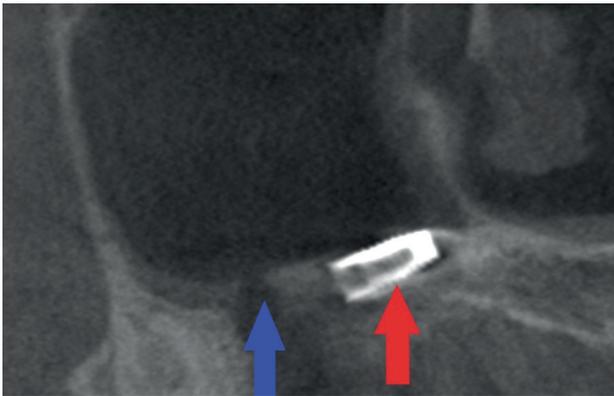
Parasagittal view of cone beam computed tomography showing breach in continuity of maxillary sinus (blue arrow) and implant in sinus (red arrow).
